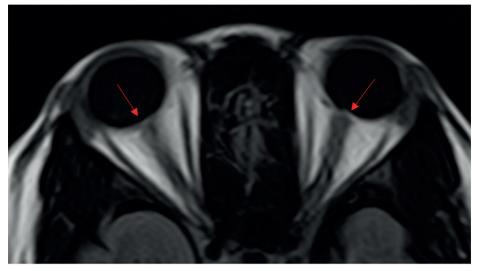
Axial cut of a fluid attenuated inversion recovery magnetic resonance image showing posterior globe flattening (red arrows).
